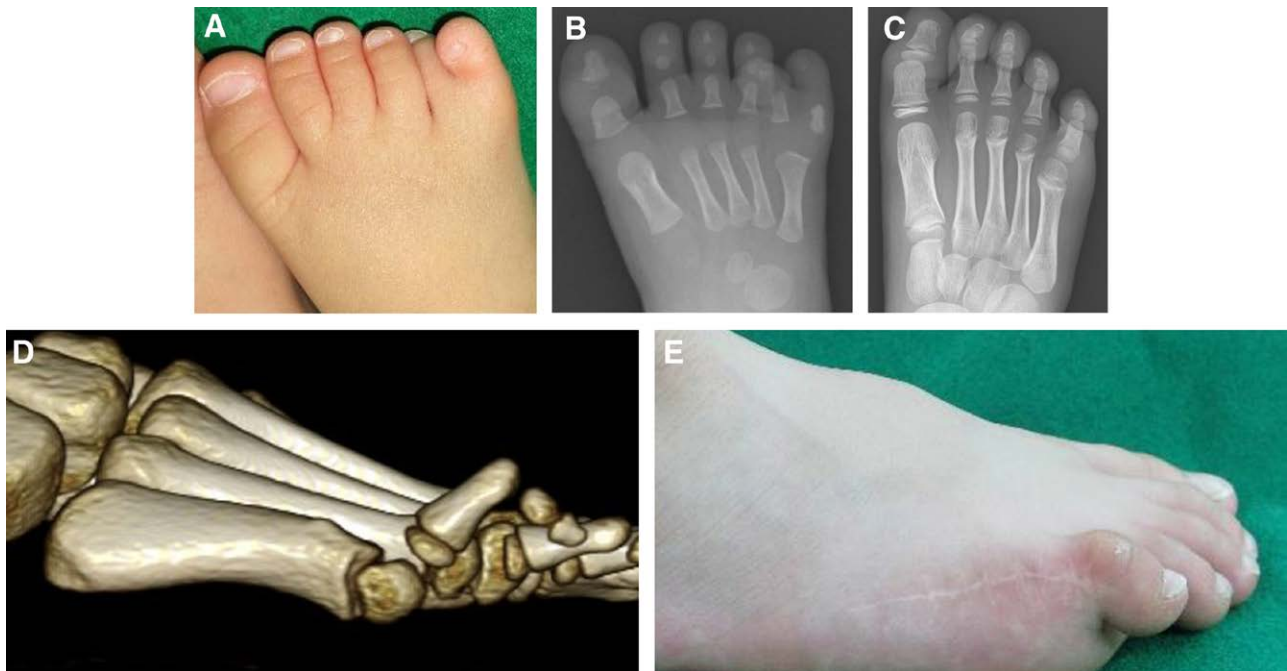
Case 1 required revision surgery due to painful hammer toe deformity. A and B, Preoperative photograph and x-ray demonstrating type A-P polydactyly. Simple excision of the sixth toe with metatarsal head shaving was performed. C–E, At age 7, the A-P x-ray displayed favorable growth of the fifth ray. The lateral view exhibited hammer toe deformity and painful scarring on the dorsal aspect of the fifth toe.
